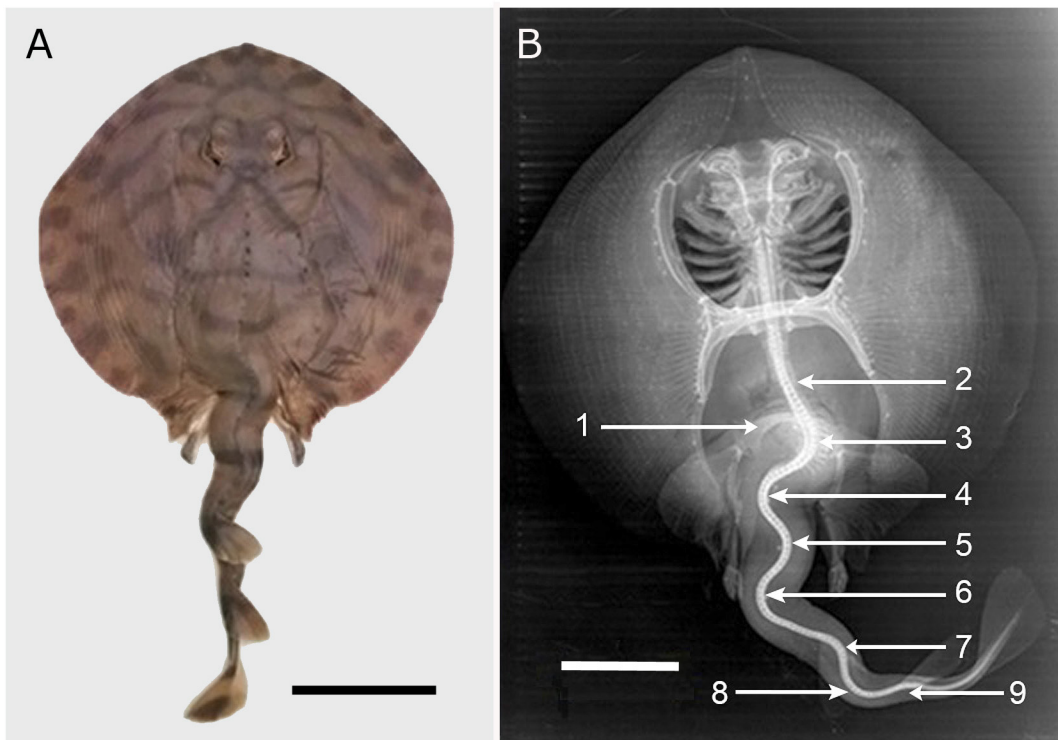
Zanobatus schoenleinii* (Ref. ISPAB-Zan-sch-05). A. Dorsal surface, scale bar= 80 mm. B. X-ray radiography indicating 1. Pelvic girdle. 2. Scoliosis of truncal vertebrae. 3-9. Tail curvatures, scale bar= 70 mm / *Zanobatus schoenleinii* (Ref. ISPAB- Zan-sch-05). A. Superficie dorsal, barra de escala= 80 mm. B. Radiografía indicando 1. Cintura pélvica. 2. Escoliosis de las vértebras del tronco. 3-9. Curvaturas caudales, barra de escala= 70 mm
